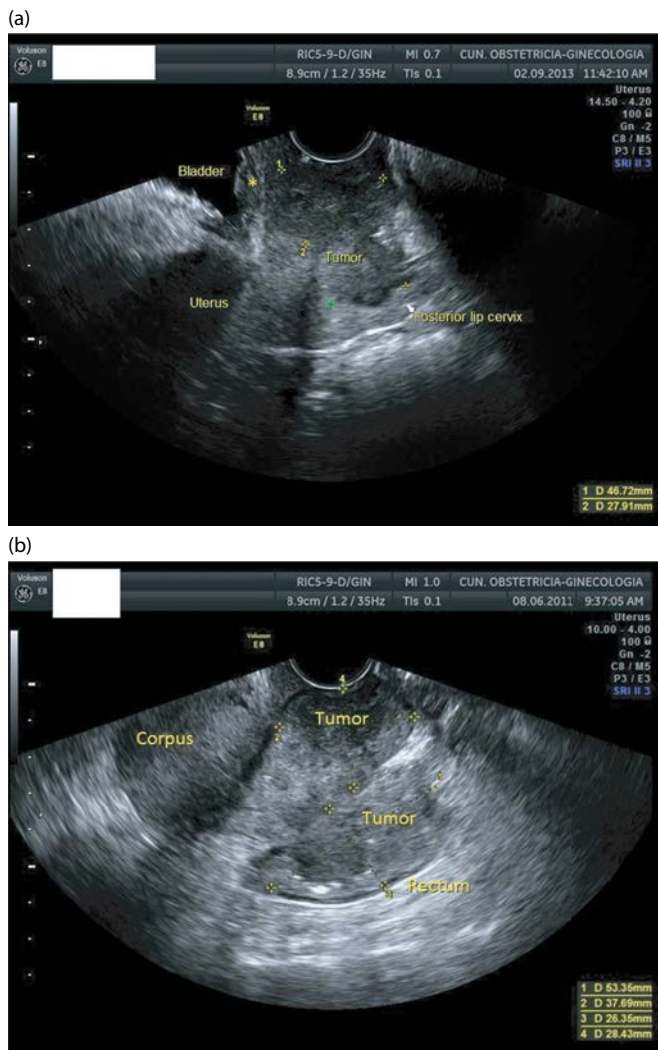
Two examples of bladder involvement (a) and rectal involvement (b) in cases of cervical cancer as depicted by transvaginal ultrasound. In case (a), the tumor reaches the bladder wall. We can observe the thickening and irregularity of bladder wall at the point the tumor is infiltrating (*). In case (b), the tumor expands posteriorly, reaching and infiltrating the anterior rectal wall.
